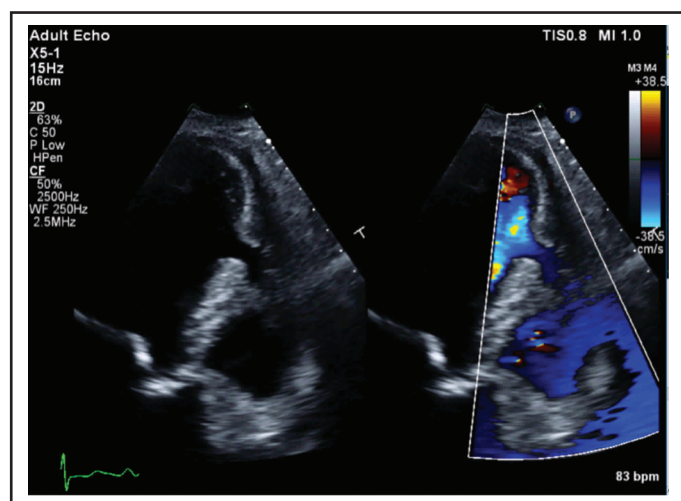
Muscular diverticulum split color. Off-axis 3-chamber view of a muscular diverticulum. Color Doppler demonstrates filling through the narrow neck and wider out-pouching into the anteroseptal wall of the LV.³
